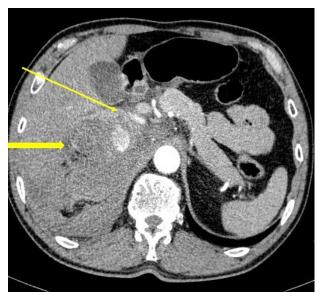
Computed tomography angiography (angio-CT), arterial phase, axial image — right adrenal mass with heterogeneous enhancement (thick arrow), suspicion of rupture of central part of the tumour with contrast extravasation to retroperitoneal space (thin arrow). Imaging result obtained from the Department of Diagnostic Imaging, Hospital in Sucha Beskidzka, Poland
